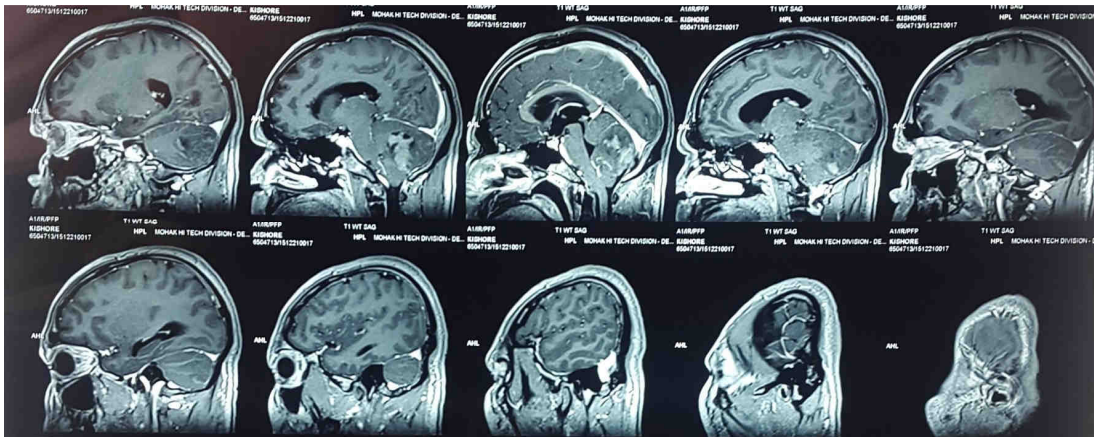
Post contrast MRI brain sagittal section showing midline cerebellar mass
